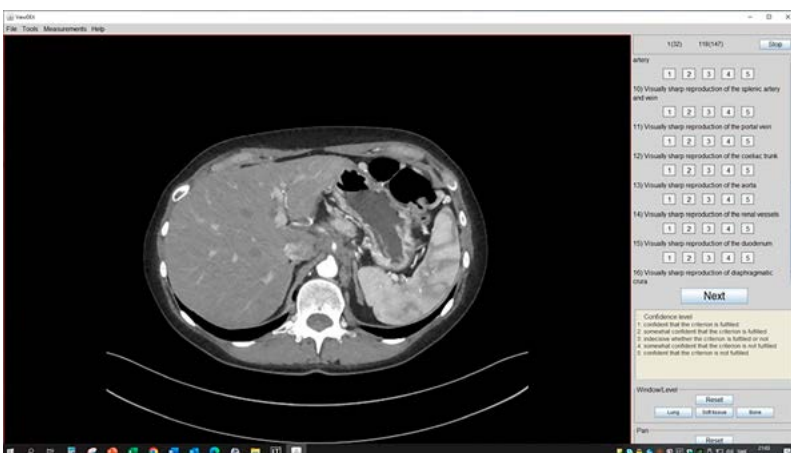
Screenshot of the evaluation done on data from the Force and the Count. The software used is Viewdex 3.0. The image quality evaluation was done with the criteria for the pancreas from the European guidelines on quality criteria for computed tomography.
